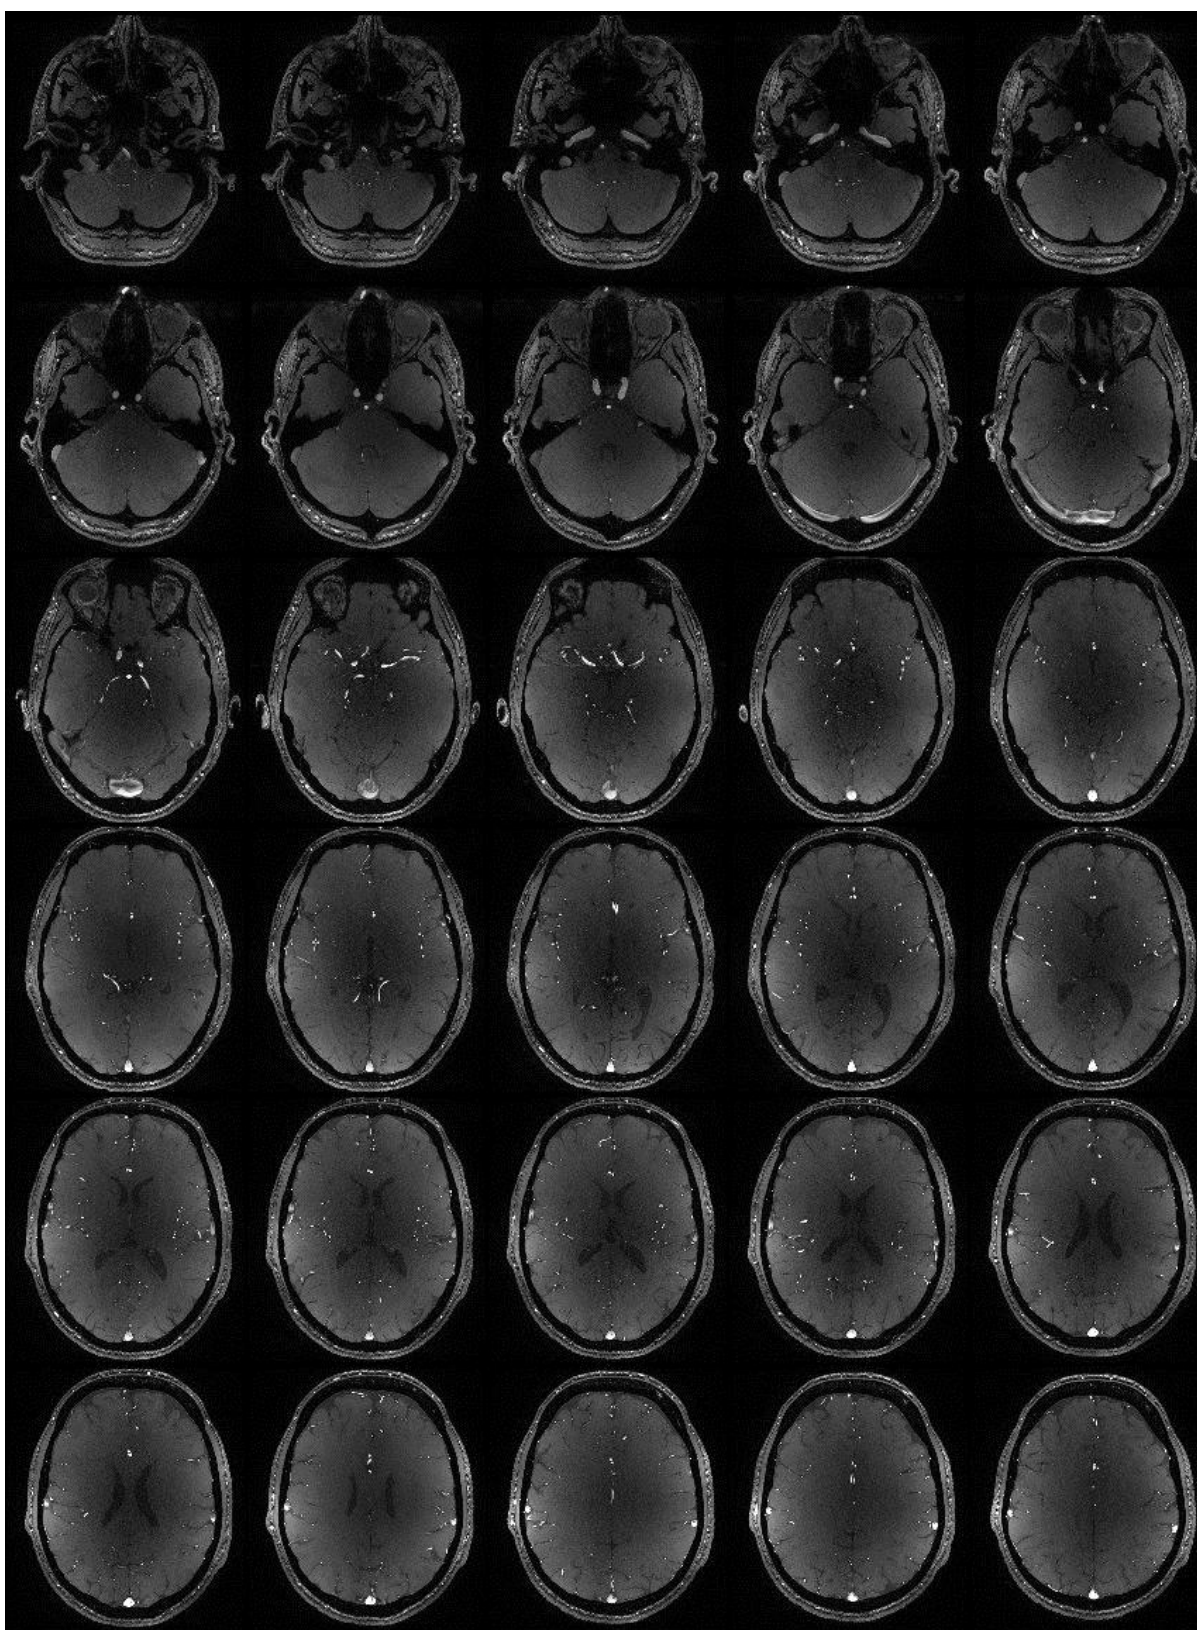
Figure B-5. MRI montage image of normal subject 5
